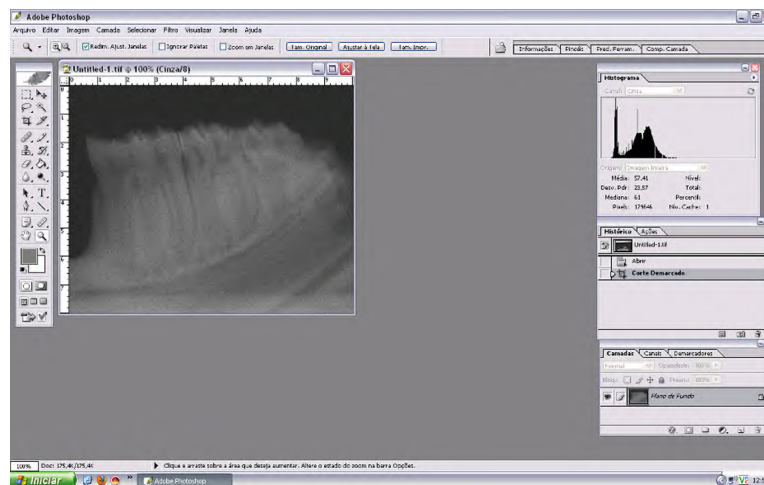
Radiographic analysis applying 100% zoom in Adobe Photoshop CS, version 8.0.1. (Adobe Systems, San Jose, CA, USA)
